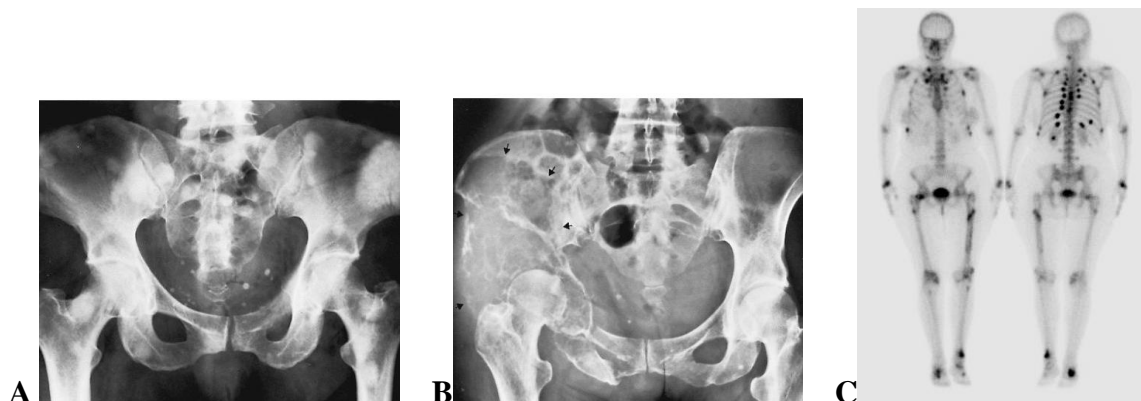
(A) Osteoblastic metastases. Multiple areas of increased density involving the pelvis and proximal femurs representing metastases from carcinoma of the urinary bladder. (B) Metastatic thyroid carcinoma. Large area of entirely lytic, expansile destruction (arrows) involves the left ilium. (C) Two scintigrams (anterior and posterior view) of skeleton same patient. Note multiple areas of increased uptake of radiopharmaceutical in the pelvis, legs, vertebrae and ribs. This indicates multiple sites of increased osteo-blastic activity in a pattern typical of disseminated skeletal metastases. Metastases seen as areas of increased uptake of tracer (areas black color), bladder is normal
